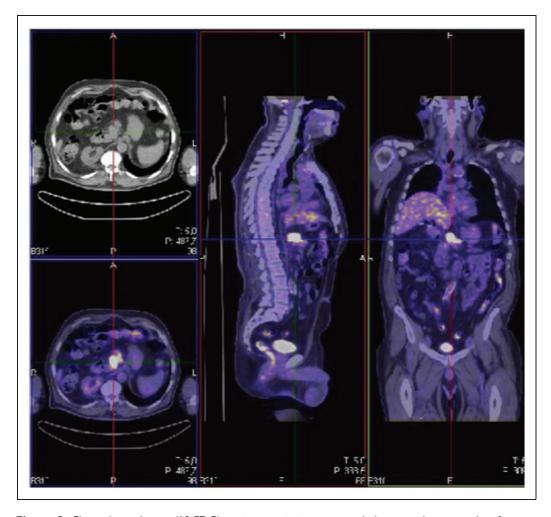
Fluorodeoxyglucose (18-FDG) positron emission tomography/computed tomography of a 71-year-old man showing pathological uptake of the 18-FDG radiotracer in the peripancreatic area with a standardized uptake volume of 14.72. The colour version of this figure is available at: http://imr.sagepub.com.
